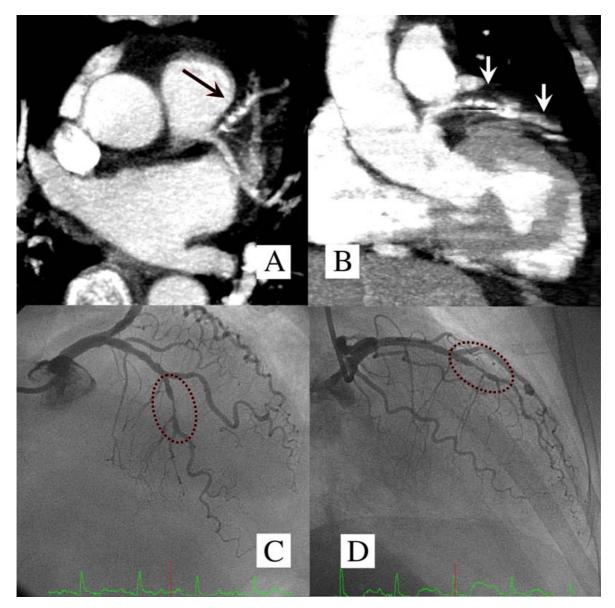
A 77-year-old female presented with dyspnea. A and B show calcium and respiratory artifacts seen at the proximal and mid LAD on CT angiogram. These effects limit in evaluation of the luminal stenosis. C and D, coronary angiogram, show no stenosis at the proximal LAD but there is short segmental severe stenosis at the middle LAD
